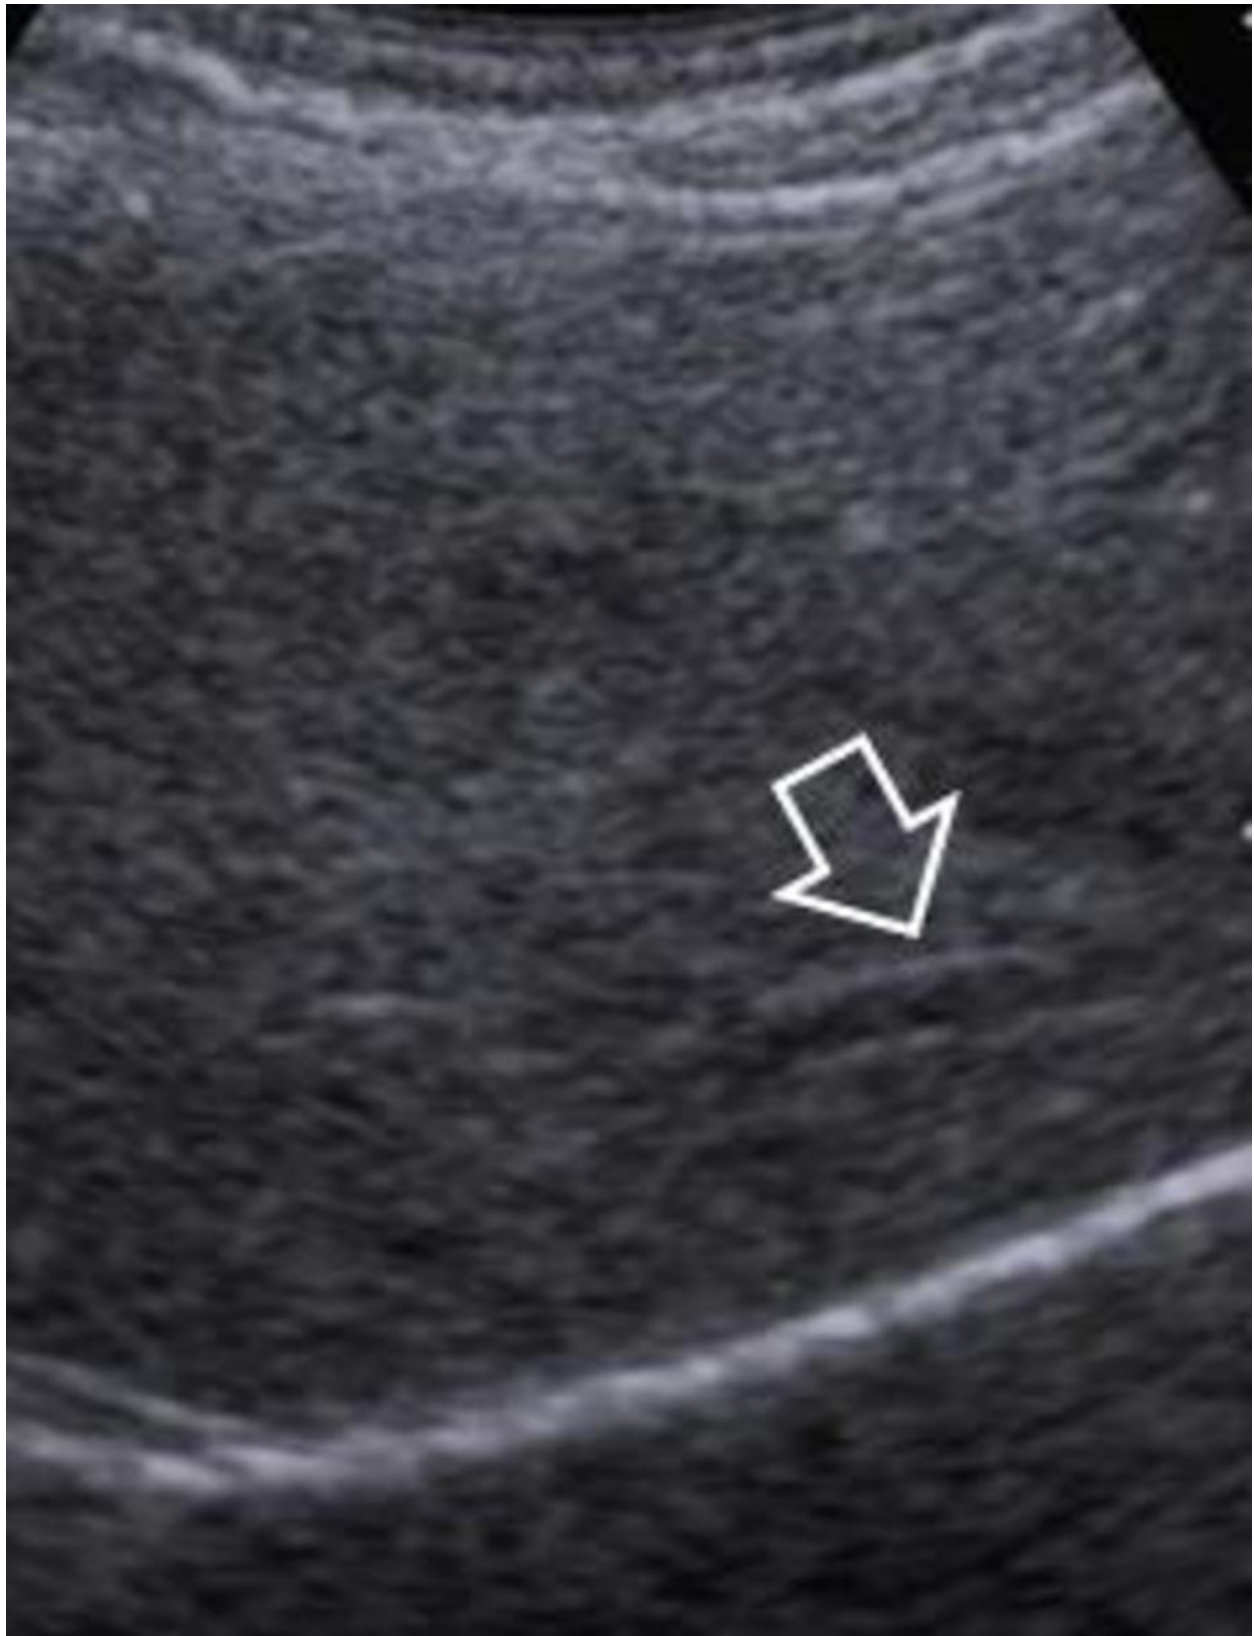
Gray scale ultrasound showing echogenic material within the lumen of the hepatic vein (white arrow).
